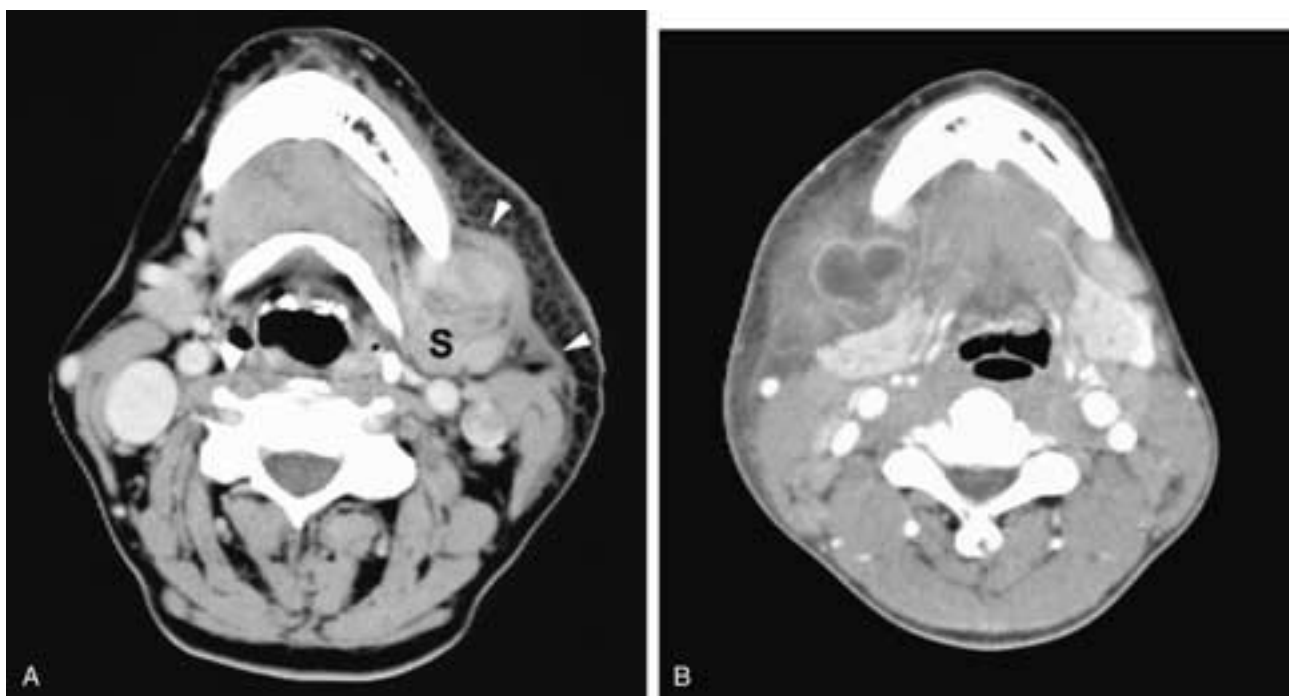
Axial contrast-enhanced CT scan (A) shows mild thickening of the skin in the left neck, marked thickening of the subcutaneous fat with prominence of dilated lymphatic and vascular capillaries and venules, and thickening of the platysma (*arrowheads*), all secondary to an acute left submandibular sialadenitis (S). Axial contrast-enhanced CT scan (B) on another patient shows the changes of cellulitis in the right submandibular triangle. In addition, there is an abscess with an enhancing rim. The abscess displaces the submandibular gland posteriorly.
